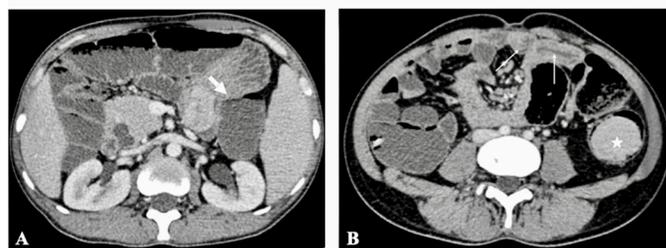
Axial contrast-enhanced CT enterography images (a and b) show large polyps in duodenum (thick arrow) and descending colon (asterisk) in a case of Peutz-Jeghers syndrome. Segments of small bowel intussusception (thin arrows) are also seen because of other smaller polyps.
